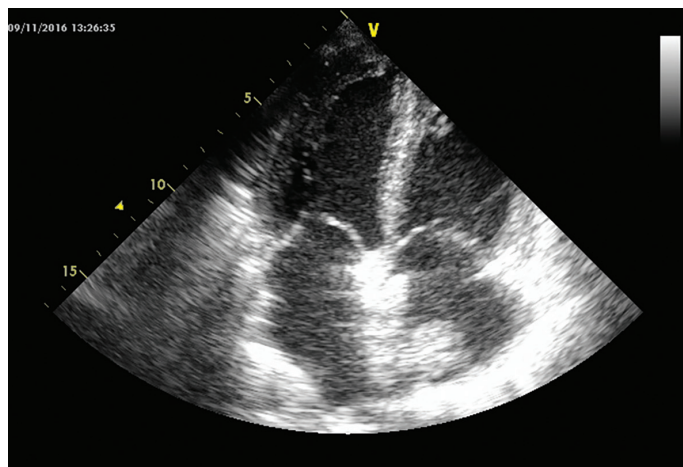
Two-dimensional apical four-chamber view showing the ball-like thrombus in the right atrium that is associated with the atrial septal defect closure device
